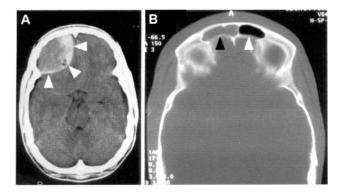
Preoperative, non-enhanced, axial computed tomograms of the brain. (A) Right frontal extradural haematoma (arrows). (B) Mucosal thickening/fluid in the right (black arrow) but not the left (white arrow) frontal air sinus, consistent with right frontal sinusitis
